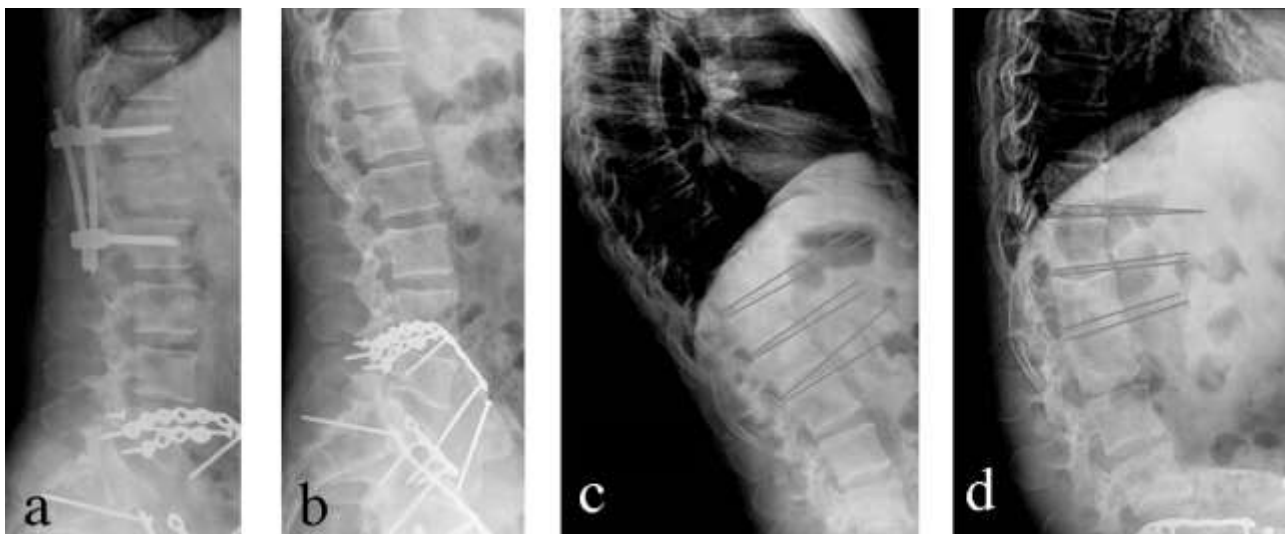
A 46-year-old male patient. Polytrauma with type A2 fracture of L1, fracture of the iliac wing and fracture of the anterior and posterior column of the left acetabulum. a): Postoperative X-ray of lumbosacral spine in lateral position; b): X-ray after instrumentation removal; c, d): X-Ray in maximum extension and maximum bending that highlight a normal ROM in all the segments examined.
